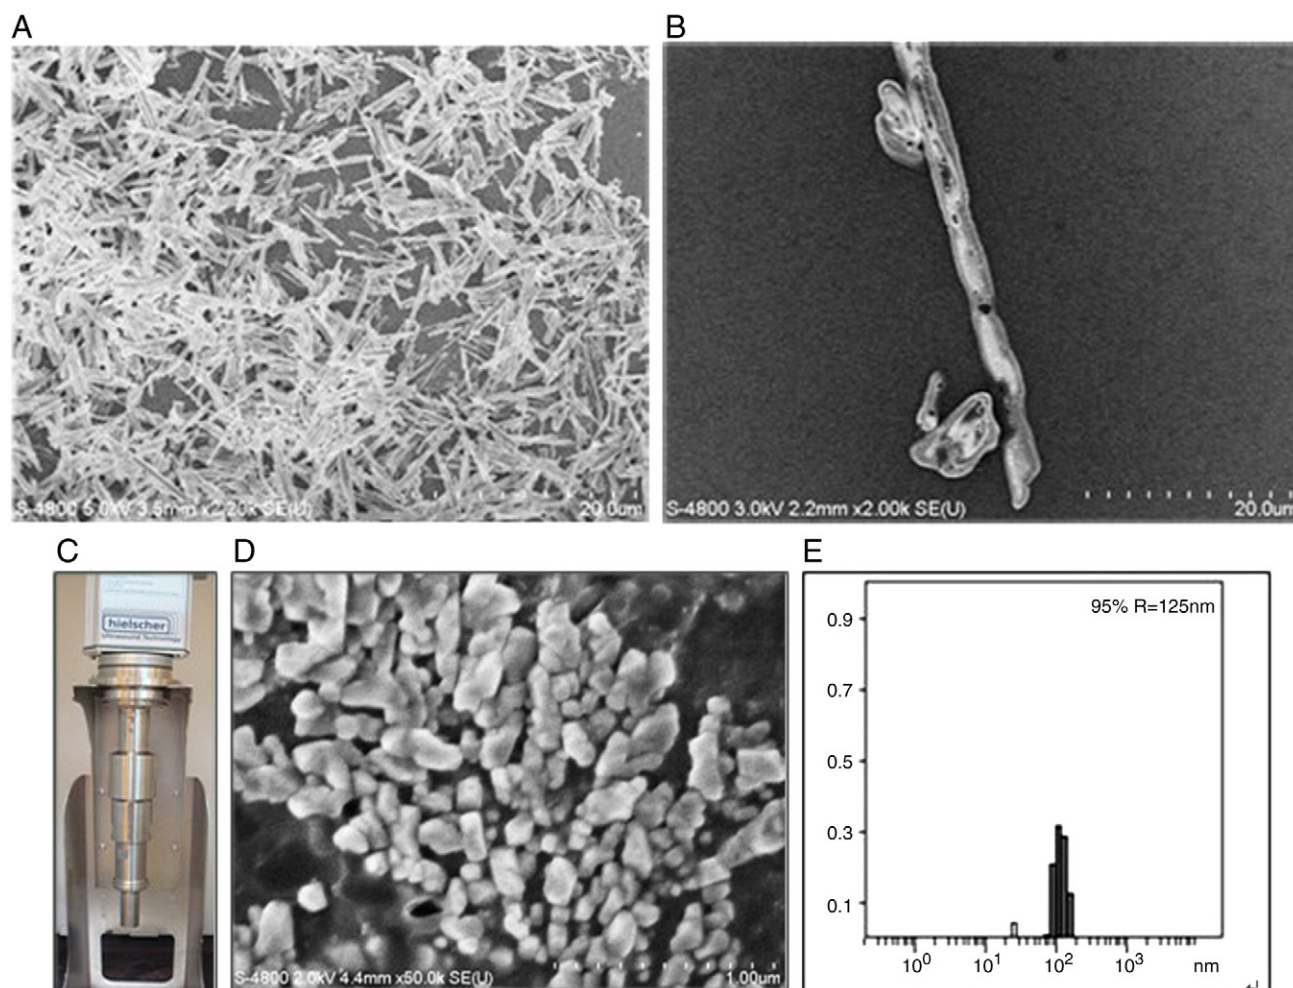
SEM image of PTX (A) and lapatinib (B) before treatment. Ultrasonication-assisted coating of first layer on PTX: (C) sonicator, (D) SEM image, (E) light scattering result.
